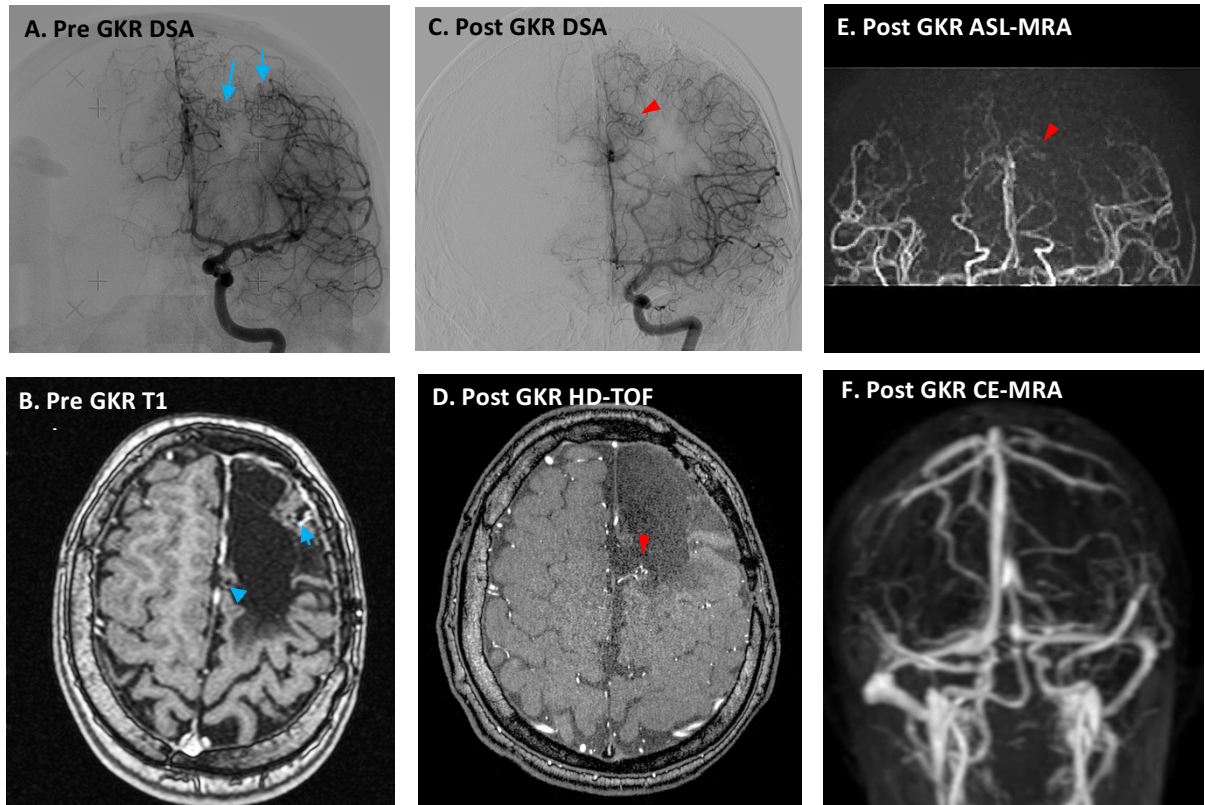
Representative case of confirmation of AVM obliteration using triple-MRA. The pre GKR DSA (A) and MRI (B) showed two AVM nodi (blue arrows) at the time of GKR in a patient with previous partial surgical excision of a ruptured AVM. The most lateral nidus is not identified in post GKR imaging; however, a residual of the most medial nidus (red arrow heads) is identified in post GKR HD-TOF (D) and ASL-MRA (E). These findings are confirmed by post GKR DSA (C). The small size of the lesion renders it not identifiable in the CE-MRA (F).
